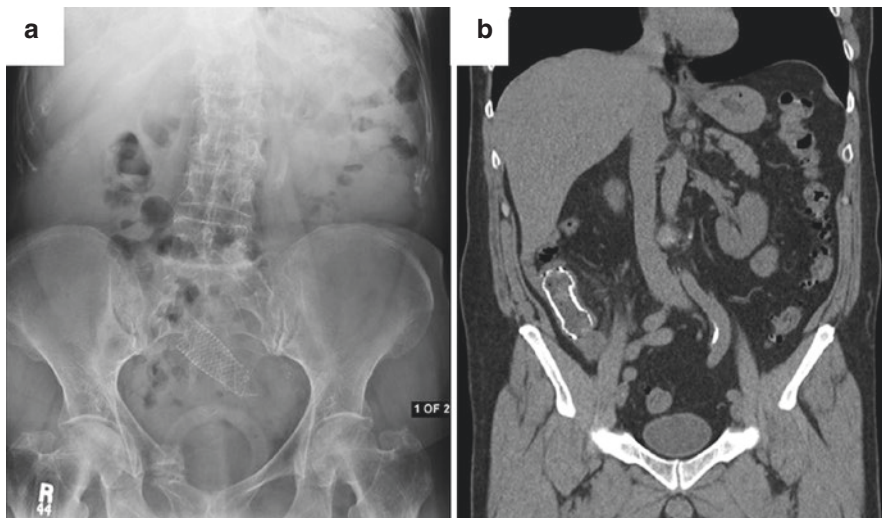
(a) Abdominal X-ray image showing migration of an uncovered duodenal stent into the distal small bowel. (b) CT image showing fully covered duodenal stent migration in another patient. Both patients required operative intervention for stent removal
